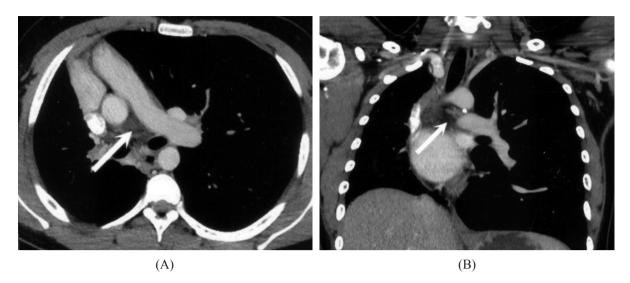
(A) Computed tomography of the chest shows absence of a right pulmonary artery from the main pulmonary trunk (arrow). (B) Coronal reconstruction reveals hypoplasia of the right lung and hyperinflation of the left lung. The left pulmonary artery is noted, whereas the right pulmonary artery is not found at the expected site (arrow).
